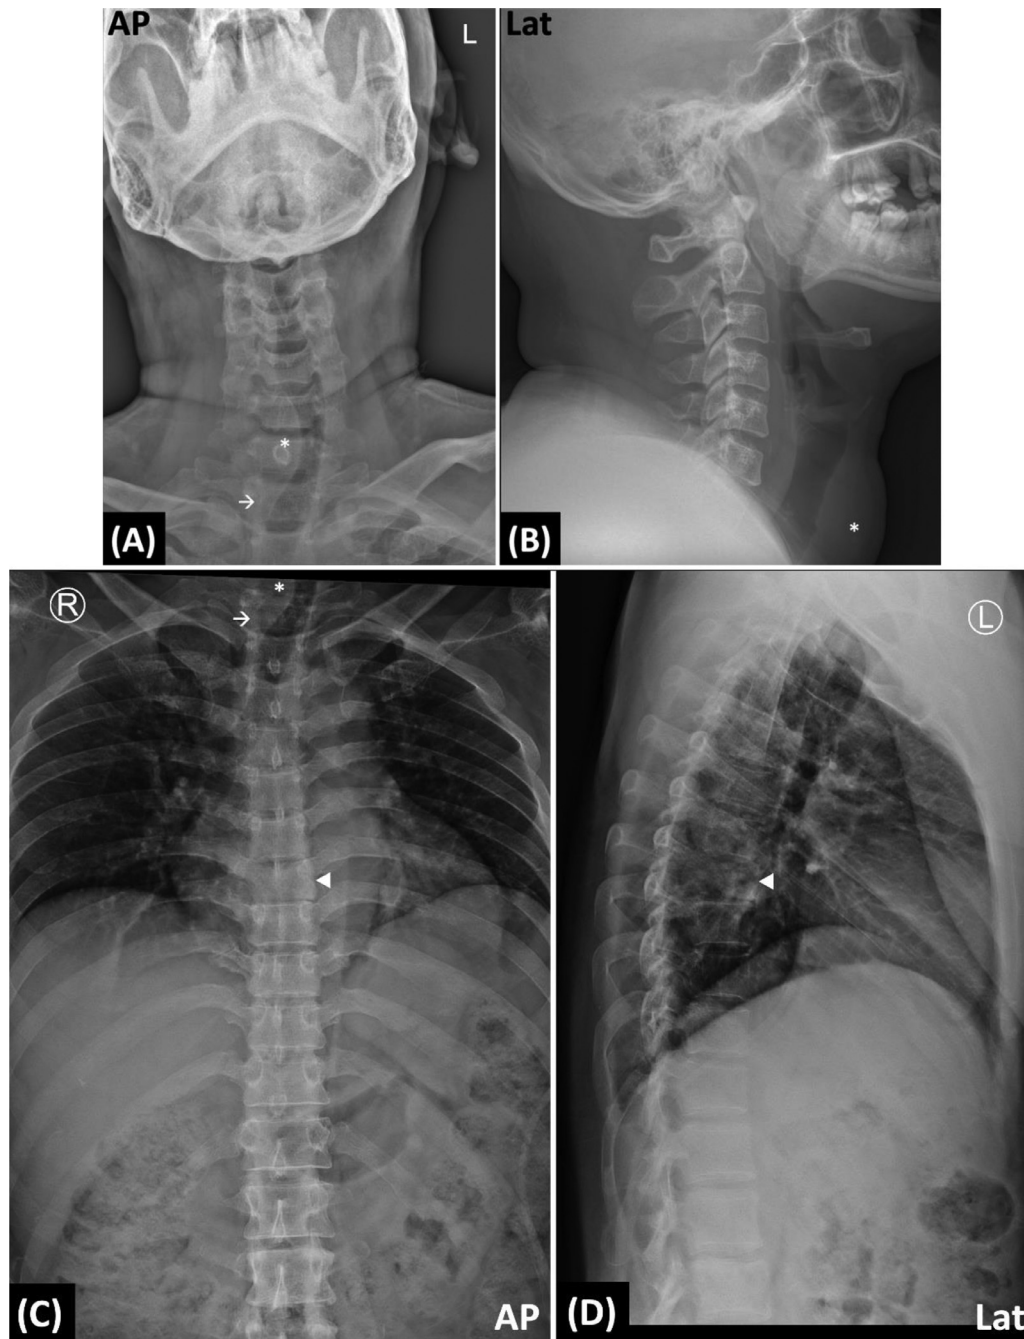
Cervical and thoracic x-ray revealed (A) and (C) Anteroposterior projection cervical and thoracic X-ray showed a soft tissue mass at C6-T1 level (asterisk) that pushed the trachea to the left. There were also blurring of the T1 pedicle (arrow) and deformity of the T7 vertebral body (arrowhead). (B) Lateral projection cervical X-ray showed soft tissue mass anterior to the trachea (asterisk). (C) and (D) Anteroposterior and lateral projection thoracic X-ray showed deformity of the T7 vertebral body (arrowhead).
